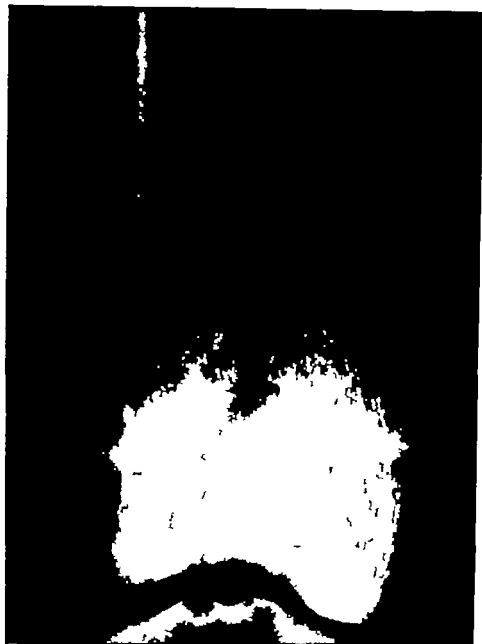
Roentgenogram of another pertinent tumor in a young man 20 years of age originating in the lower epiphysis of a femur and extending into the metaphysis. The tumor has provoked some sclerosis of the surrounding spongy bone. The biopsy sections in this case were overdiagnosed as osteogenic sarcoma and amputation was performed on the basis of this mistaken impression.
